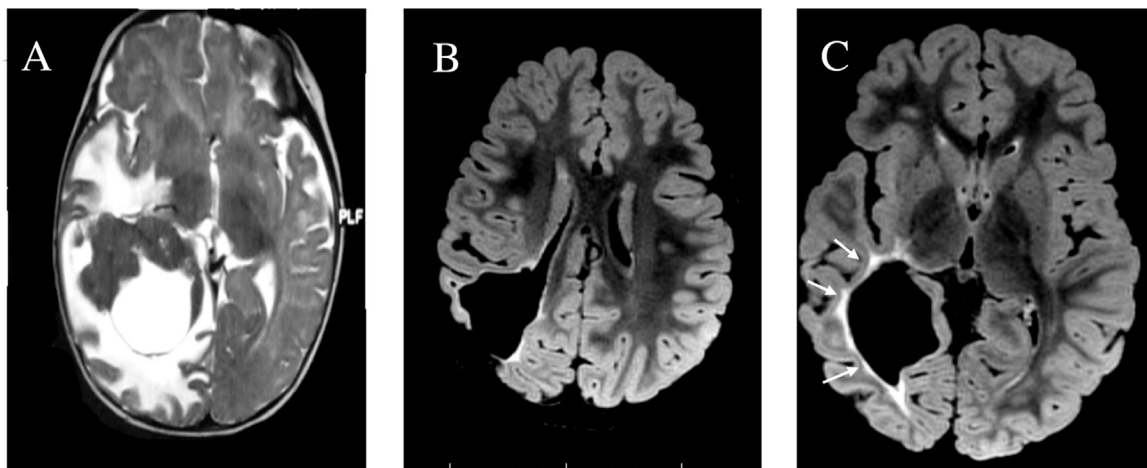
Pre and post surgery MRI scan. Panel A: Pre-surgical MRI T2-weighted image on the axial plane. Intra-cerebral intra-ventricular edematous expansive lesion with wide compressive effect on deep temporo-parietal-occipital region and the surface of the brain. Panel B, C: Post-surgical MRI FLAIR-T2 images on the axial plane. Wide porencephalic post-surgical intra-axial cavity, communicating with lateral ventricle and brain surface (B). The hyperintensity relative to gliosis surrounding the post-chirurgical cavity follows the hypothetical stream of the optic radiations (C, white arrows).
